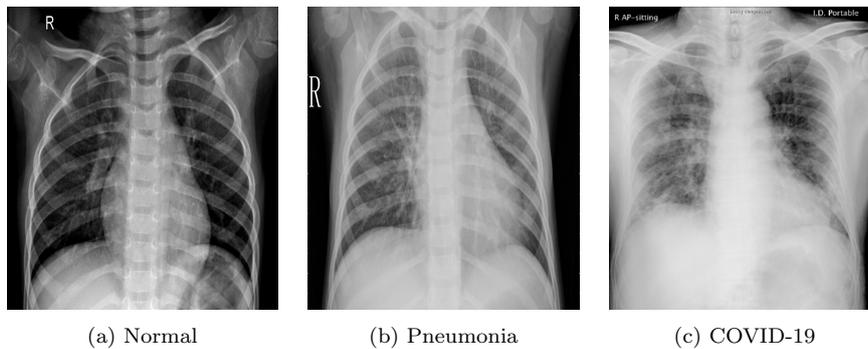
Examples of Normal, Pneumonia infected and COVID-19 infected chest X-Ray images.
